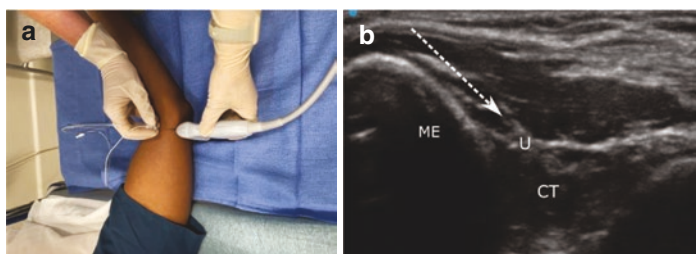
Ulnar nerve block at the arm. (a) Patient position and needle entry point. (b) Sonoanatomy of ulnar nerve in cubital tunnel. U—ulnar nerve; ME—medial epicondyle, CT—cubital tunnel, long arrow—needle direction and target point
